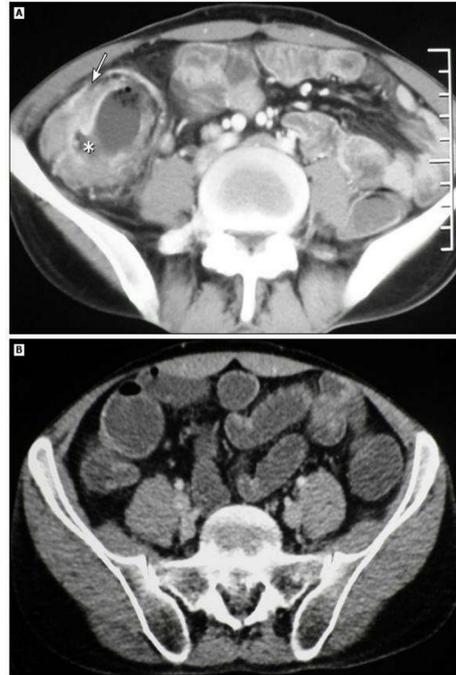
Axial images from contrast-enhanced CT demonstrating (A) ileocecal involvement (arrows) with ulceration (asterisk) and (B) complete resolution of radiographic findings after six months of anti-tuberculous therapy.
